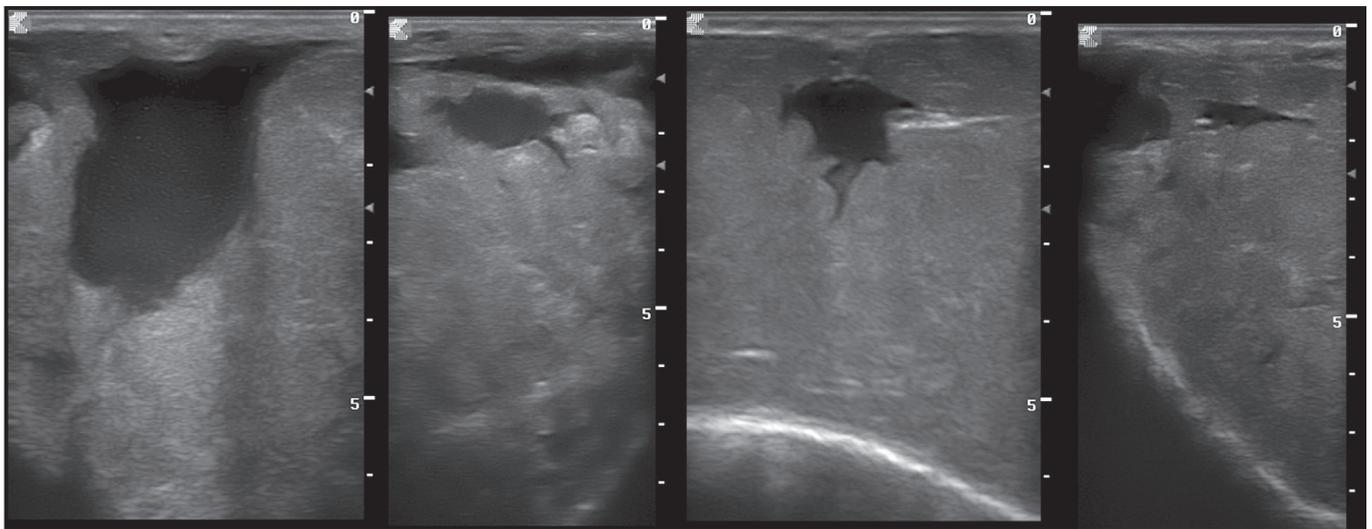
Ultrasonogram of a buck testis showing ruptured albuginea and hemorrhage.
